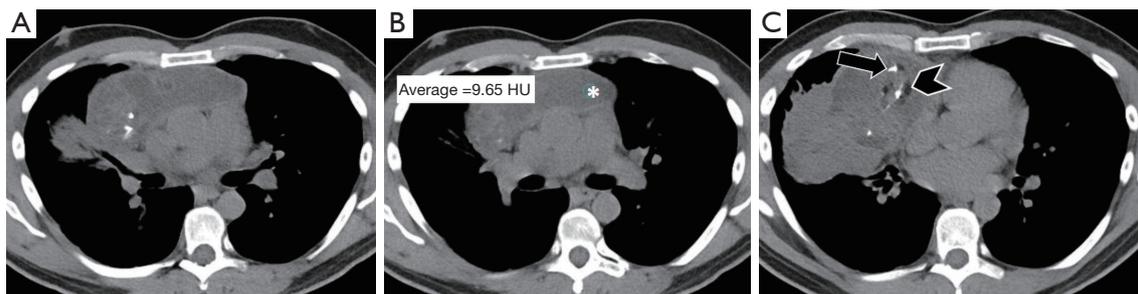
36-year-old male with a cystic teratoma. CT images without intravenous contrast demonstrated a large cystic and solid mass centered in the pre-vascular mediastinum (A). Note is made of areas of low-density (B, asterisk, HU =9.65; C, arrow) and high-density (C, arrowhead) compatible with fluid, fat deposition, and calcification, respectively. Pathology confirmed teratoma with cystic changes. CT, computed tomography; HU, Hounsfield unit.
